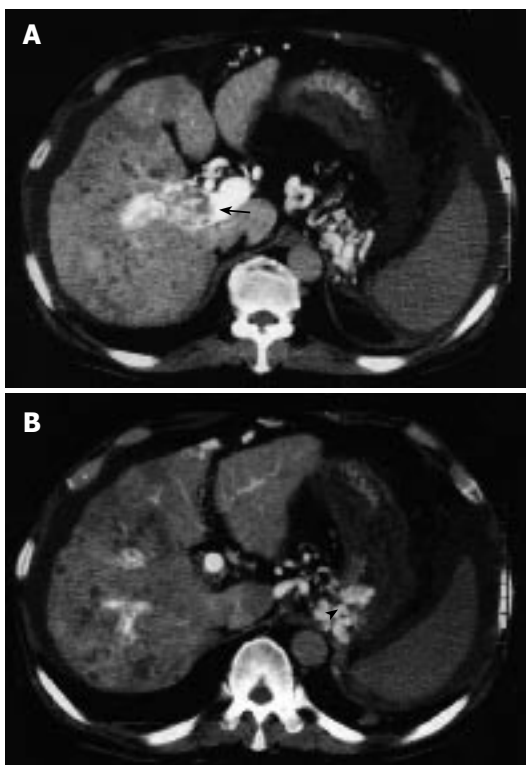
CT during proper hepatic arteriography showing tumor thrombi (arrow) in the right portal vein (A) and gastric varices (arrowhead) (B).
